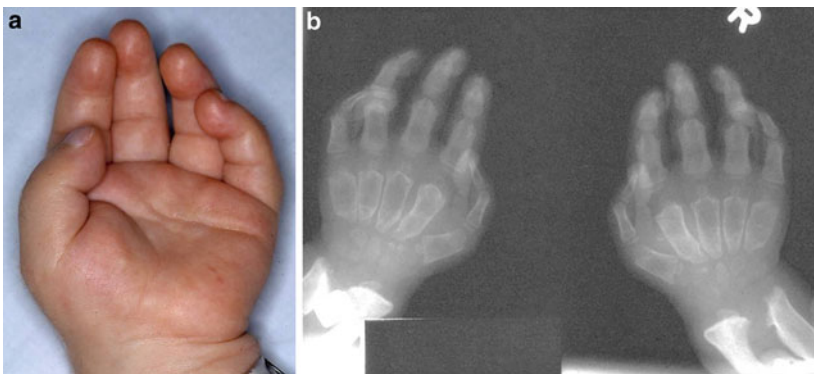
(a, b) Claw hand. The radiographs show thick bullet-shaped phalanges, proximal narrowing of the metacarpals, poorly ossified carpal bones, and angulation toward each other of the distal ends of the radius and the ulnar
